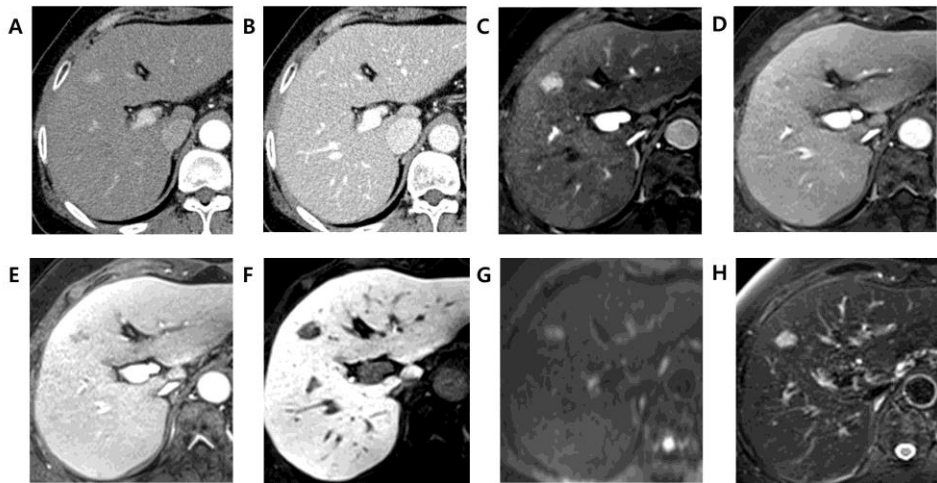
61 year-old woman with Edmonson grade II HCC. Liver dynamic CT (A-B) taken on January 2nd, 2009 with (A) non-rim arterial phase hyperenhancement (APHE) in arterial phase and (B) washout in portal venous phase. Gadoxetate-enhanced liver dynamic MRI (C-H) taken on February 27th, 2009 (about 2 months later from prior
